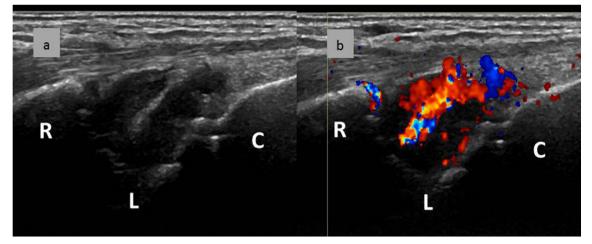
a Longitudinal ultrasound image of the radio-carpal and mid-carpal joint that shows B-mode synovitis. b Longitudinal ultrasound image of the radio-carpal and mid-carpal joint that shows B-mode and Doppler synovitis; *R* radius, *L* lunate, *C* capitate
